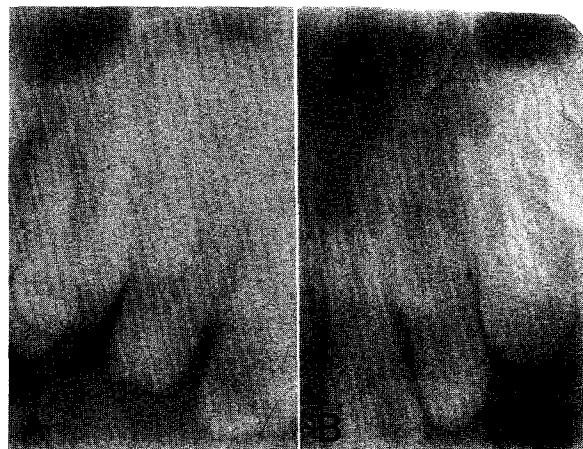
Periapical radiographs. A, Right; B, left.
